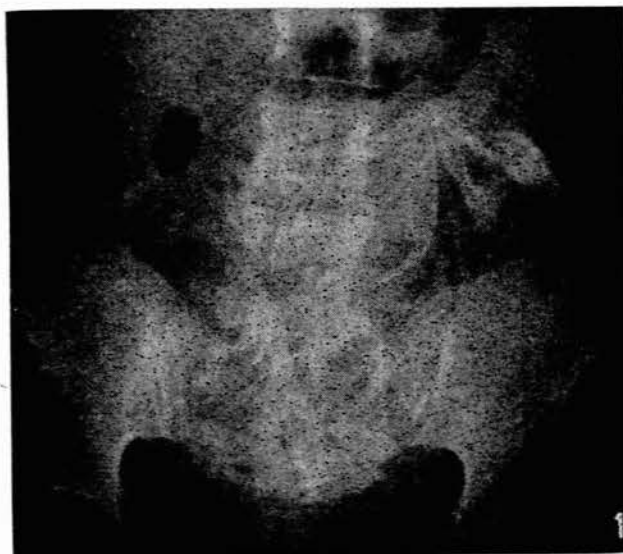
Straight X-ray of the abdomen showing the disarticulated skeleton in the pelvis.
